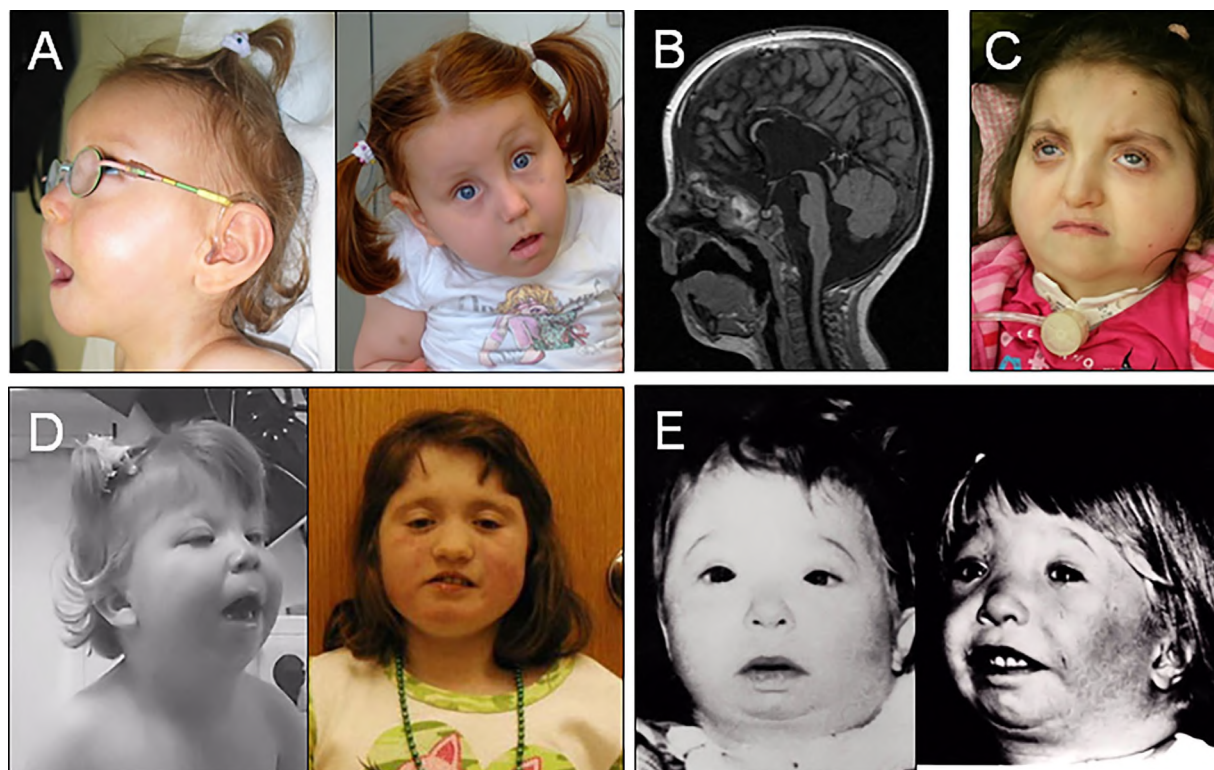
(A) Patient 1 at 20 months and 4 years of age. Note flat face with full cheeks, short palpebral fissures (18 mm), a short nose with underdeveloped alae nasi, thin upper lip vermilion, downturned corners of the mouth, and micrognathia. (B) MRI of patient 1 at 19 months of age. Note hypoplasia of corpus callosum. (C) Patient 2 at 4 years of age, showing flat face with full cheeks, widely spaced eyes, short and downslanting palpebral fissures, short philtrum, thin upper lip vermilion, downturned corners of the mouth, and micrognathia. (D) Published patients with T-CS (Toriello et al., 2003: Figs. 1 and 4) showing flat face, short palpebral fissures, and full cheeks. (E) The originally described patients with T-CS (Toriello & Carey, 1988: Figs. 3 and 4) [Color figure can be viewed at wileyonlinelibrary.com]
